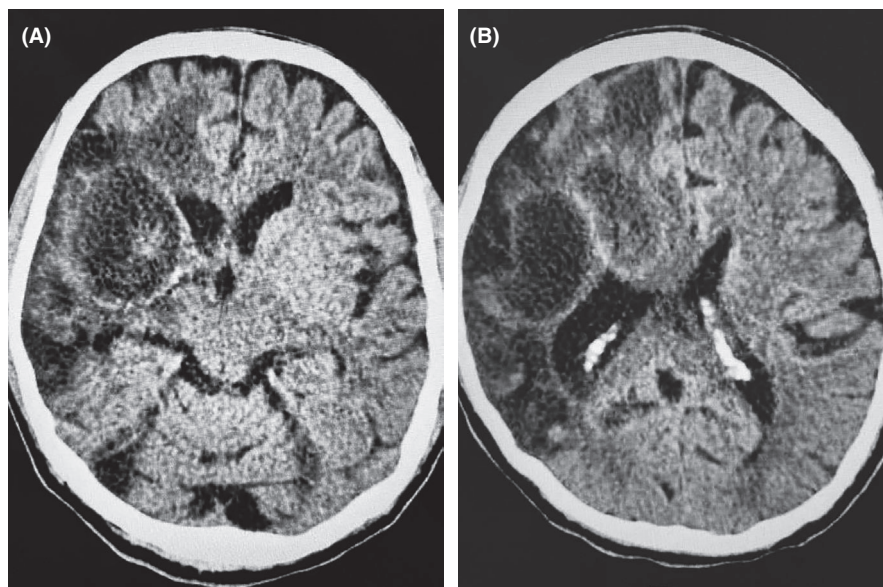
A, B CT with contrast images
